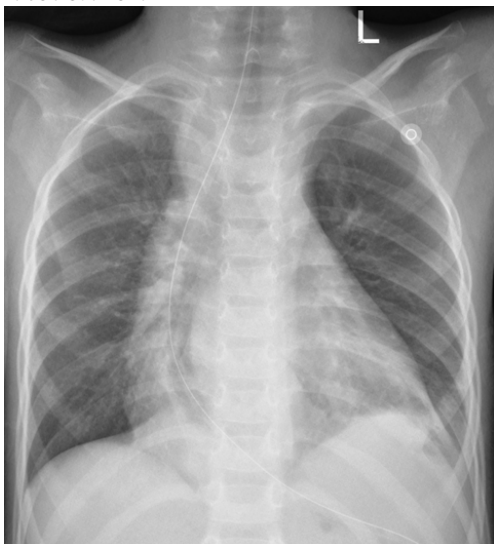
Chest Radiograph Showing Right Para Cardiac Opacity With NG Tube In The Right Side Of The Thorax.
